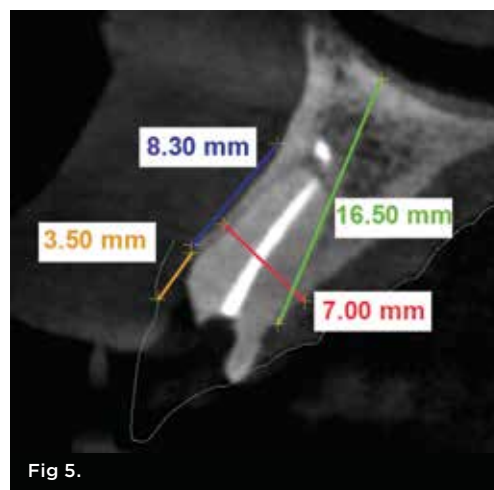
Static Guide One with small C-guide sleeve (left); apex removal and socket-shield preparation instruments (right), including guided osseodensification burs equipped with small gauge and G-stop. Fig 2. Static Guide Two with medium C-guide sleeve (left); implant site preparation instruments (right), including guided osseodensification burs equipped with medium gauge and G-stop to prepare the implant site. Fig 3. Mesial-distal split and shield preparation instruments. Fig 4. Initial presentation, facial view. Maxillary right lateral incisor had hopeless prognosis due to subgingival caries and horizontal fracture of the crown. Fig 5. Initial diagnostics CBCT with the four measurements for SPOT: root length in the bone (blue line), distance from the gingival margin to the buccal bone (yellow line), alveolar bone length (green line), and alveolar bone width (red line). Fig 6. Digital guided treatment plan of the SPOT two trajectories: apex removal trajectory and implant site trajectory. Fig 7 and Fig 8. Guided SPOT digital planning: Fig 7: Occlusal view with two trajectories—apex removal trajectory (red) and implant site trajectory (green). Fig 8: Custom figure (red) representing Densah bur VT1828 (2.3) dimension depicting trajectory one for complete apex removal/shield preparation; final implant position (green) trajectory two; titanium abutment (blue), temporary crown with emergence profile, and custom implant position planned. Fig 9 and Fig 10. Static Guide One plan: produce apex removal and socket-shield preparation guide using the small C-guide with guided pilot (Fig 9) and Densah burs VT1525 and VT1828 (Fig 10).
